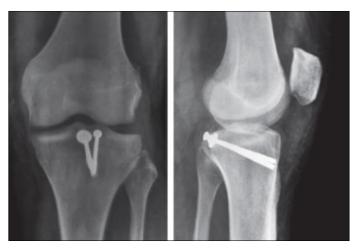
Post-operative Xray after 1 year the procedure
